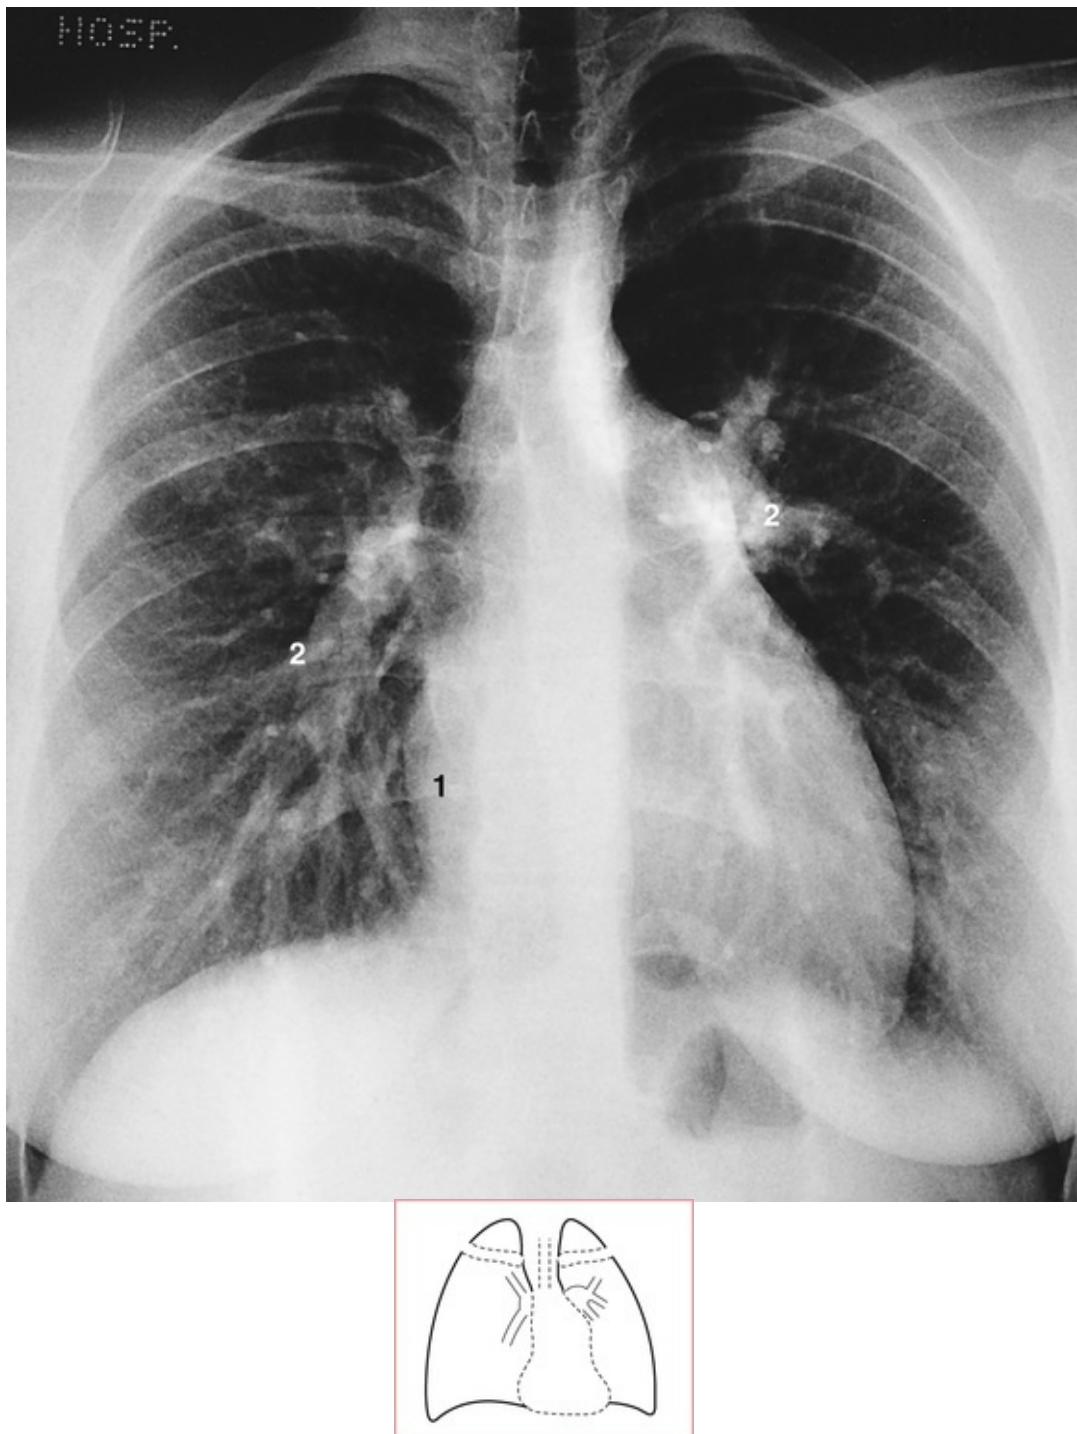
This x-ray shows the typical appearance of an atrial septal defect. The heart is enlarged, the apex is rounded, the right atrium prominent (1) and the pulmonary arteries are dilated (2) due to increased pulmonary blood flow.
